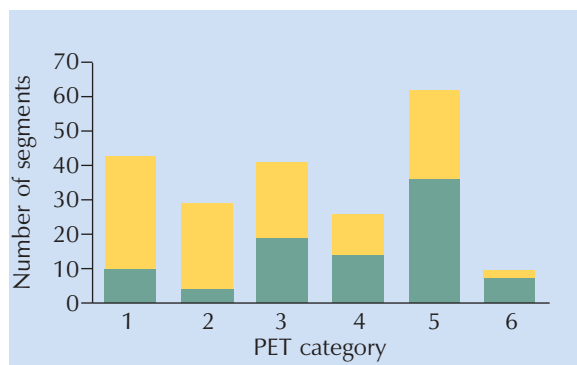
Distribution of segments with (yellow portions) and without (green portions) contractile reserve according to the six categories of perfusion and [¹⁸F]FDG uptake. Category 1: reduced perfusion and moderate FDG reduction; category 2: proportional reduction of perfusion and FDG; category 3: perfusion metabolism mismatch; category 4: preserved perfusion but moderate reduction of FDG; category 5: preserved perfusion and FDG uptake; category 6: normal perfusion and increased FDG uptake.⁴¹
